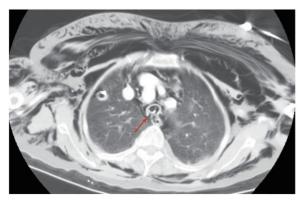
Computed tomography (lung window) shows subcutaneous emphysema and focal defect at right posterior aspect of lower trachea with paratracheal air (arrow).
